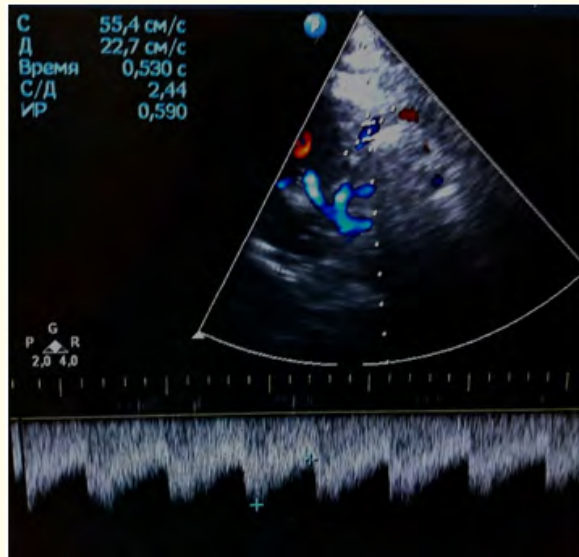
The Doppler spectrum of blood flow was obtained from the descending part of the third segment of the vertebral artery using a sector transducer. Vs is 55,4 cm/c, RI - 0,59.
